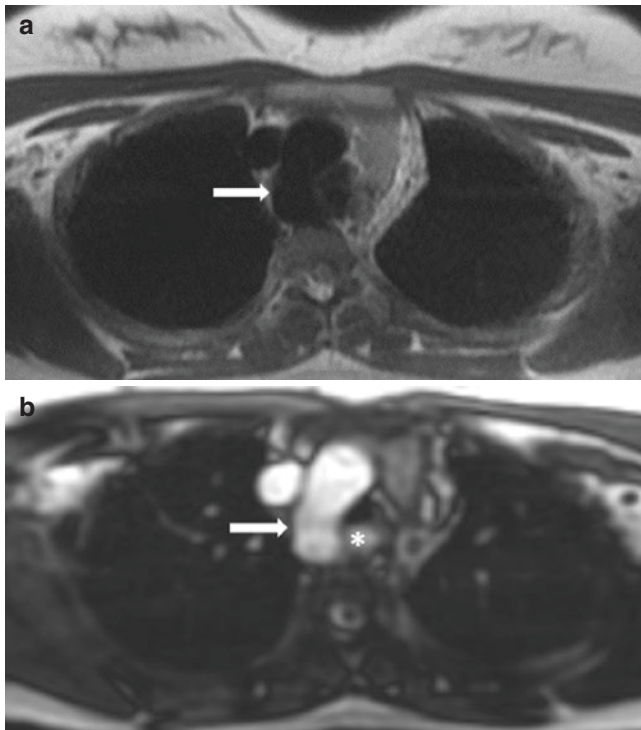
A 12-year-old girl with right-sided aortic arch and aberrant left subclavian artery. (a) Axial 2D BB SSFSE MR image shows the abnormal position of arch the aortic (arrow), located on the right side of the mediastinum, consistent with the right aortic arch. (b) Axial 2D SSFP MR image demonstrates the right aortic arch (arrow) with an aberrant left subclavian artery (asterisk) passing posterior to the trachea and esophagus
